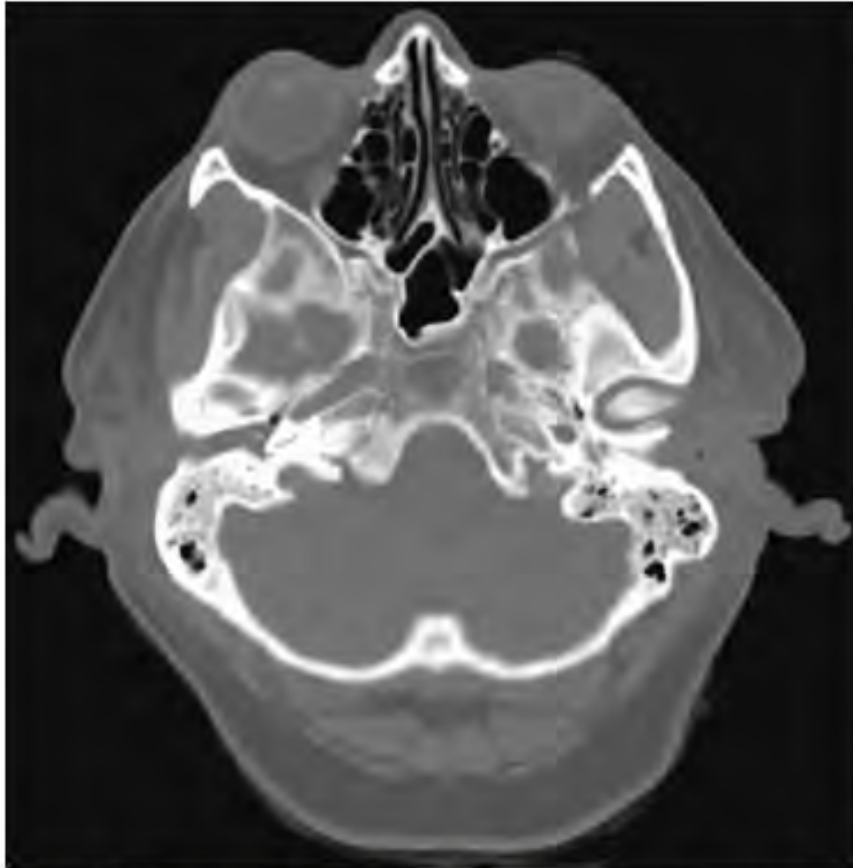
Computed tomography scan showing opacification of the bilateral mastoid air cells.
